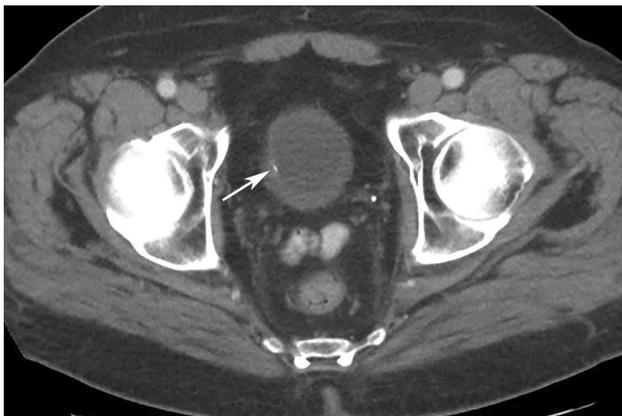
An axial portal venous phase contrast-enhanced CT image through the pelvis in a patient who has undergone radiation therapy for prostate cancer demonstrates the bladder to be small and thick-walled. There is a focus of linear mural calcification along the right lateral wall of the bladder
